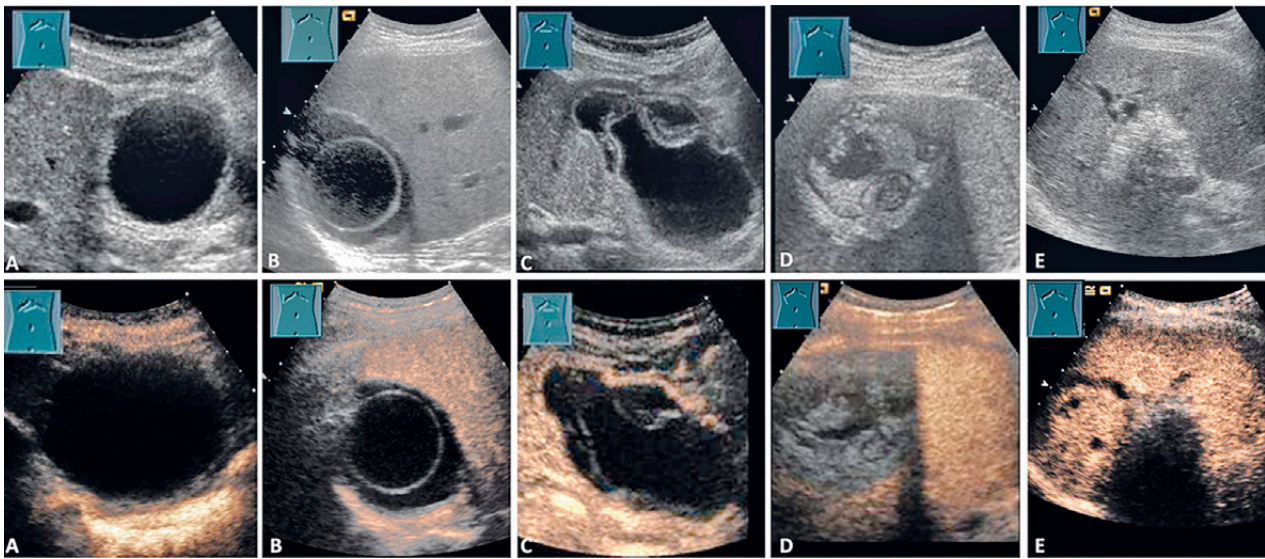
A 67-year-old patient with serologically confirmed cystic echinococcosis and with corresponding patterns of liver involvement on B-mode and contrast-enhanced-ultrasound: (A) type I (pure cyst); (B) type II (cyst within cyst); (C) type III (water lily sign); (D) type IV (solid impinging); and (E) type V (calcifications).
